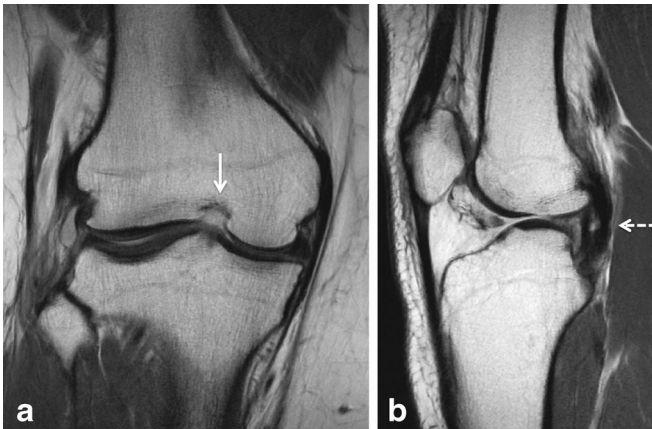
Magnetic resonance image demonstrating a an absent ACL with a stenotic notch (*white arrow*) and b a thin and vertically oriented PCL (*dotted arrow*).
